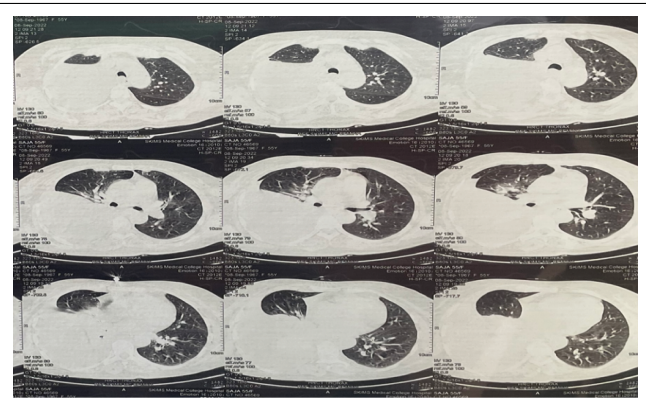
CT showing moderate right pleural effusion with passive collapse of right lower lobe.
